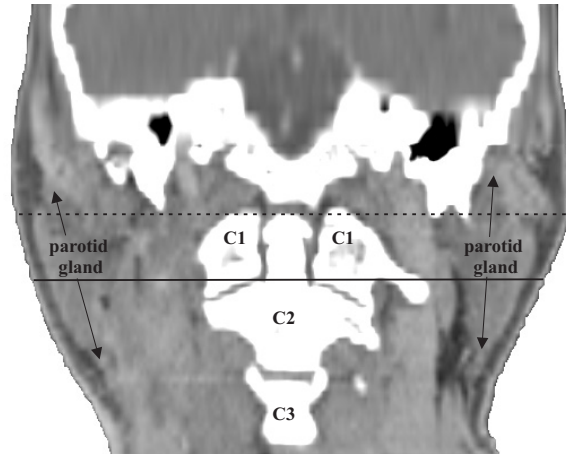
A coronal reconstructed CT-image through the cervical vertebral bodies 1, 2 and 3 (C1,C2,C3). The black lines represent the cranial edge of the target volume for lymph node region II, as respectively defined by Gregoire et al. (solid line) and Nowak et al. (dashed line). The black solid lines with arrows indicate the cranio-caudal extent of the parotid glands.
